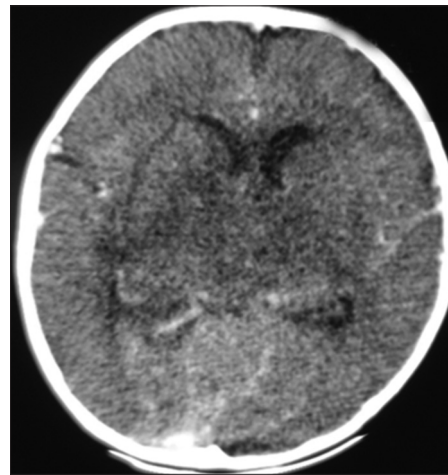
Contrast-enhanced head CT showing hypodensity involving bilateral thalami and basal ganglia
